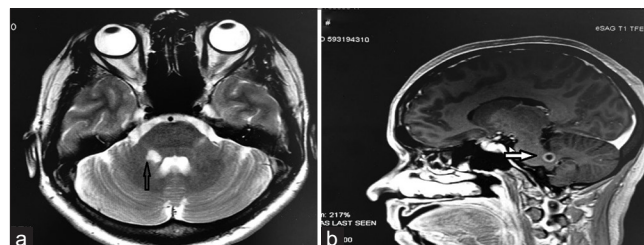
(a and b) Brain MRI with the presence of T2 hyperintense lesion with ring enhancement in the topography of the transition between the bridge and the right middle cerebellar peduncle and signs of increased signal intensity with thickening and enhancement by means of contrast of the left trigeminal nerve and at the level of its path at the level of the transition between the bridge and the left middle cerebellar peduncle.
